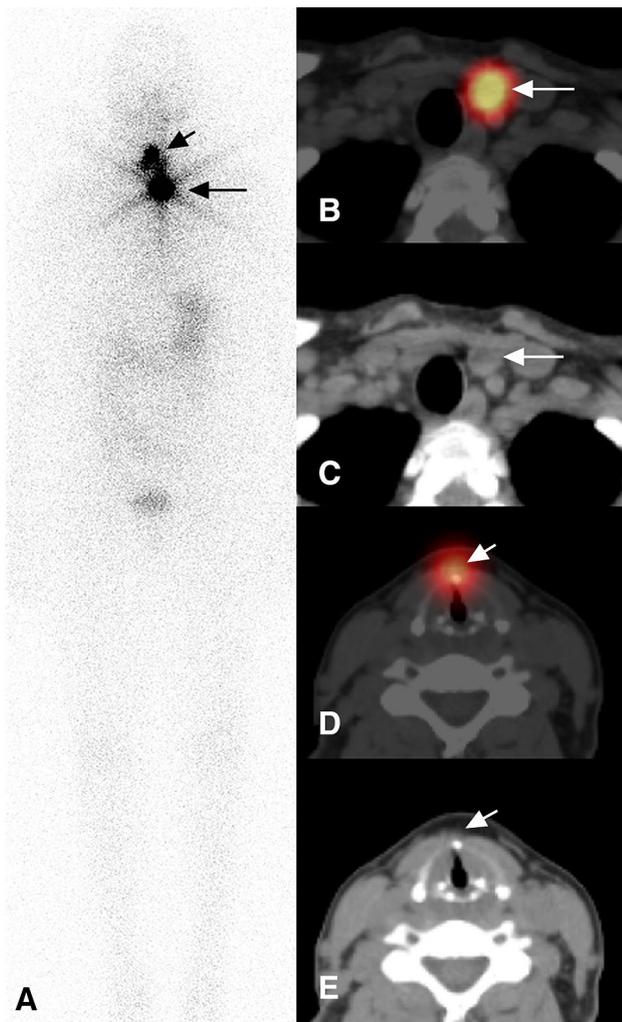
Thyroglossal duct remnant and nodal metastases. Pre-ablation I-131 SPET-CT scan in a 59-year-old woman with multifocal papillary thyroid cancer, the largest lesion measuring 1.4 cm in the left lobe, without capsular or vascular invasion, no extrathyroidal extension and negative surgical margins; 0/2 central lymph nodes were negative for metastatic disease. Post-surgical thyroglobulin was 44 ng/mL with a TSH of 57 mIU/L. She was pT1b N0 Mx, stage 1, initially classified as low risk not requiring radioiodine ablation. Planar scan (a) depicts two foci of neck activity with the inferior focus (*long arrow*) corresponding on SPET-CT (b, c) to a small iodine-avid cervical level VII lymph node with central necrosis. The superior focus (*short arrow*) corresponds on SPET-CT (d, e) to the tip of the hyoid bone (*short arrows*) compatible with thyroglossal duct remnant tissue. After imaging, the patient was restaged as T1a N1b M0, stage 4A, and re-classified as intermediate ATA risk with a recommendation for medium dose I-131 treatment (color figure online)
